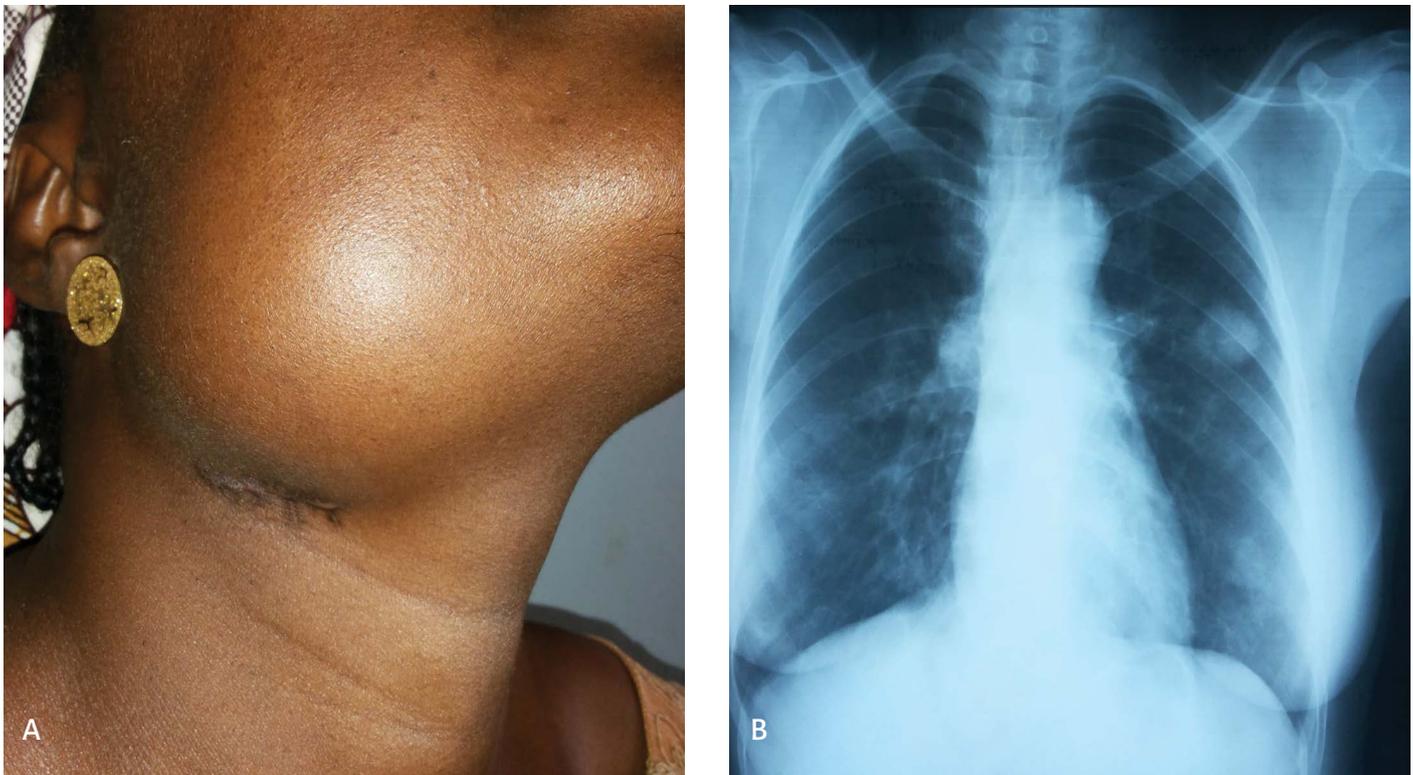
A case of rhabdomyosarcoma of the parotid and submandibular region. (a) Lateral view (b) chest radiograph showing pulmonary metastases.
